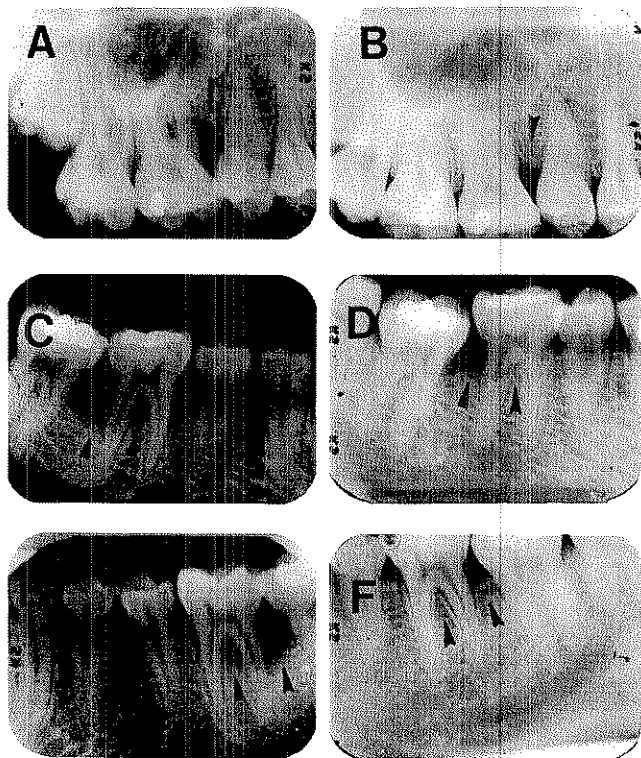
A,C,E. Case #1, radiographs with vertical defects, November 1976. B,D,F. Case #1, radiographs demonstrating osseous repair, May 1981.
